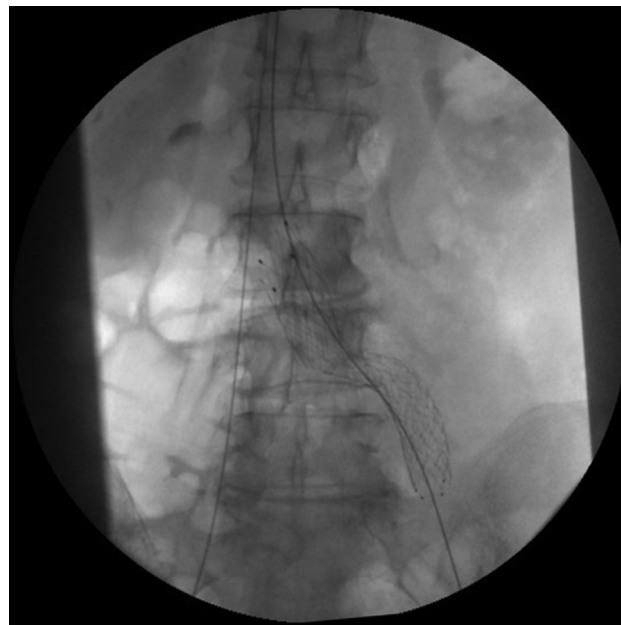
Monitoring Xray with the right iliofemoral guidewire joining the left iliofemoral guidewire in the inferior vena cava.
